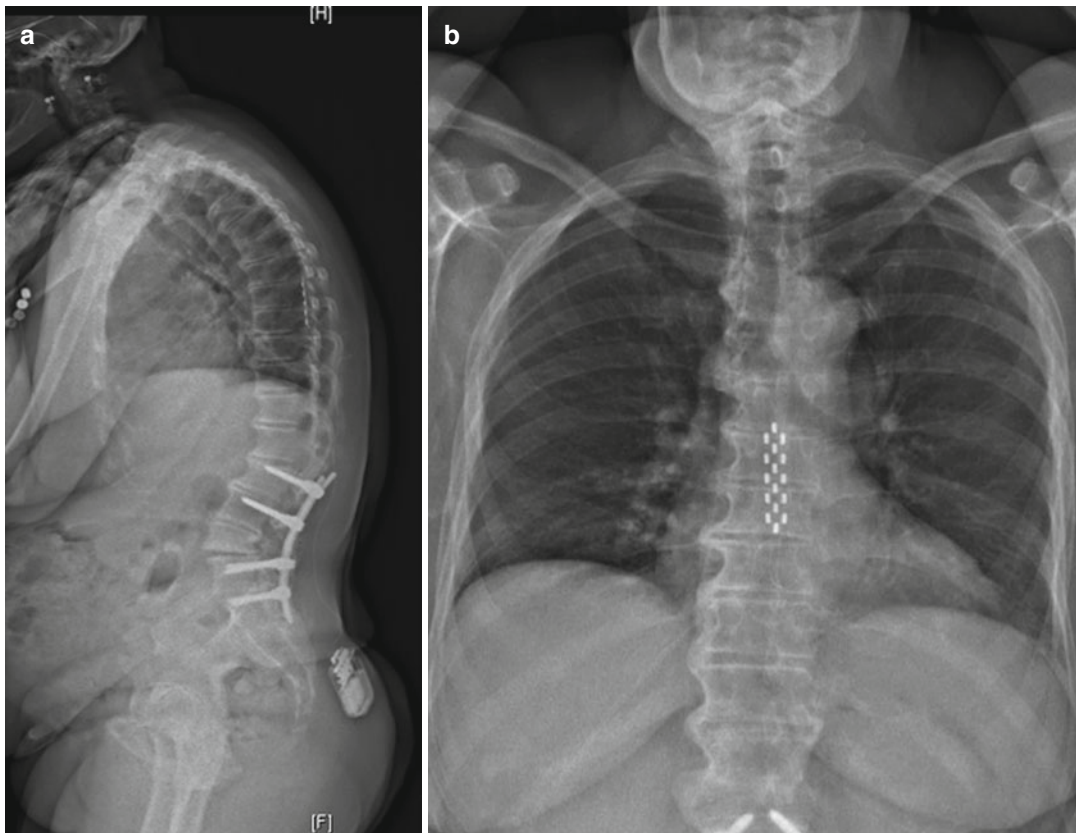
Specify 5-6-5 lead (Medtronic) at T8 level for failed back surgery syndrome including lumbar pain and radicular pain. (a) profile X-ray, (b) front X-ray
